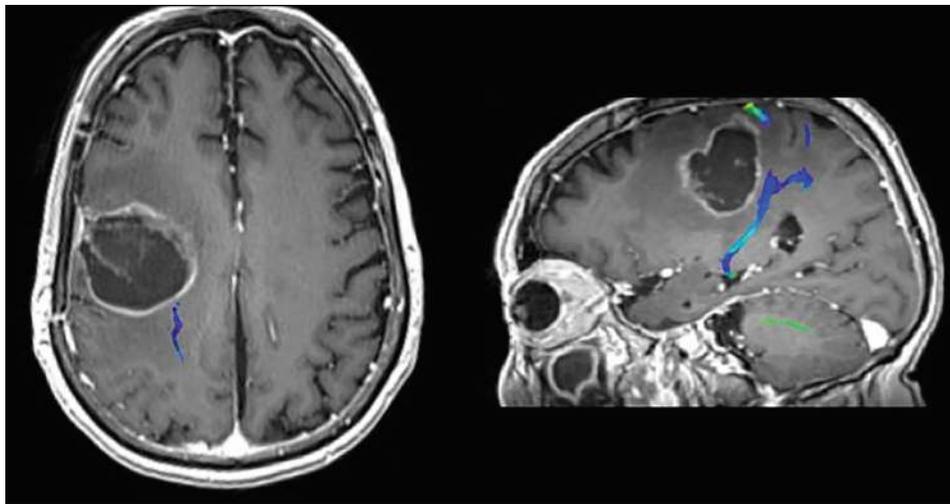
MR tractography using DTI technique. DTI imaging was performed to localize the right corticospinal tract in this patient with a right frontal lobe glioblastoma. This tractography data was fused to the T1-weighted contrast-enhanced MRI to demonstrate the precise anatomic relationship of the corticospinal tract to the tumor.
